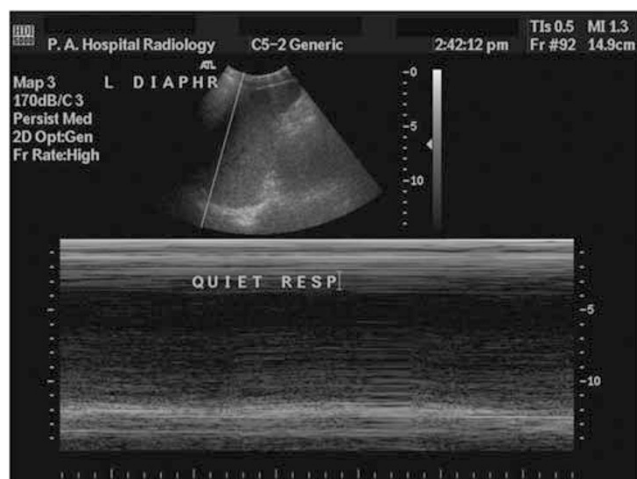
M mode ultrasound trace of paralyzed diaphragm. A paralyzed diaphragm demonstrates absent movement with respiration
